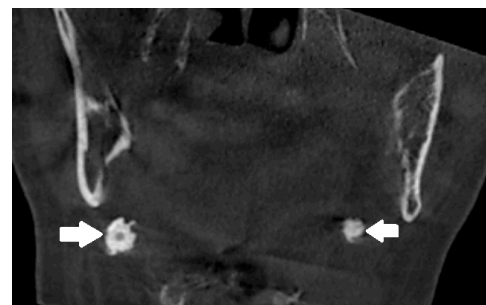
Coronal CBCT image of bilateral submandibular sialoliths (arrows).
